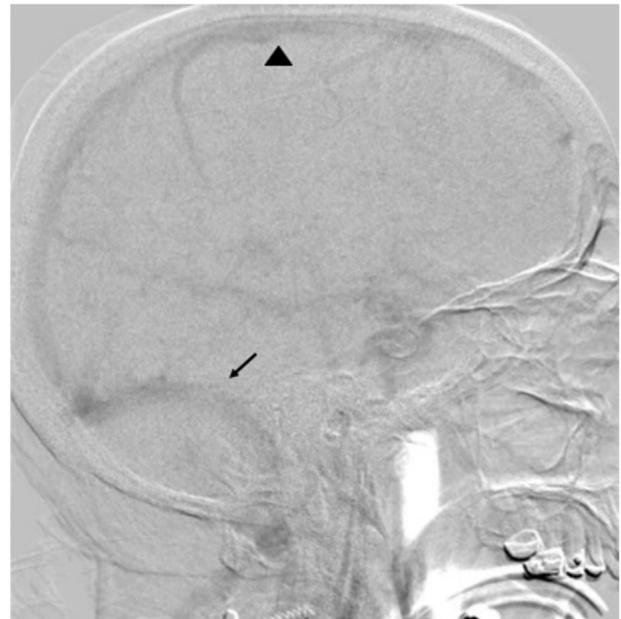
Bolus Tracking Acquisition for FP-CTA. Dilute contrast fills the major sinuses (arrowhead = sagittal sinus; arrow = transverse-sigmoid junction), indicating brain parenchymal contrast saturation adequate for rotational acquisition of the FP-CTA.
